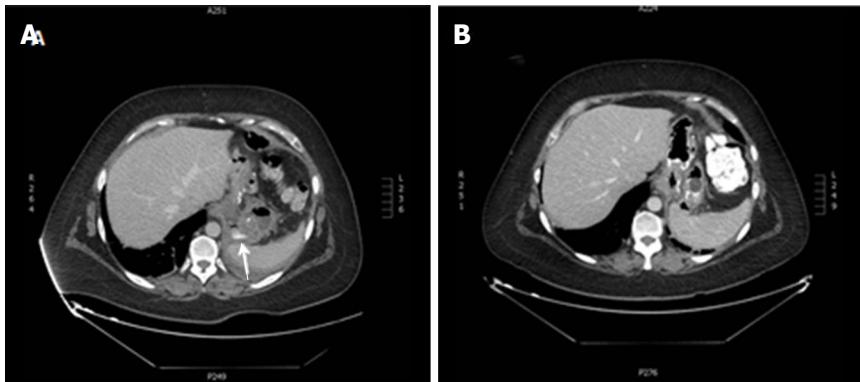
Leak resolution after stent deployment. A: The same gastrogastro fistula (arrow) as in Figure 5 confirmed by CT scan with oral water-soluble contrast. A fully covered self-expandable metal stent was inserted. The stent was removed after forty three days and a complimentary injection of fibrin glue was performed; B: A new CT scan revealed the fistula closure. CT: Computed tomography.
